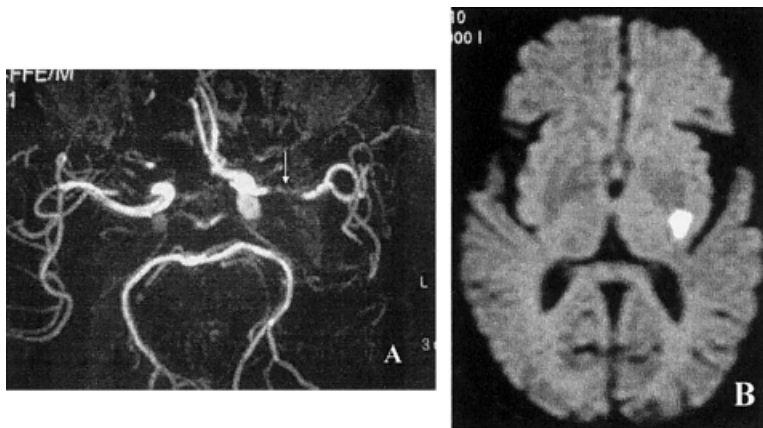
A 63-year-old man had sudden onset of right-sided weakness. (A) Magnetic resonance angiography showed severe stenosis on the left middle cerebral artery stem. (B) Diffusion-weighted magnetic resonance imaging demonstrated a single infarct in the left perforating artery area.
